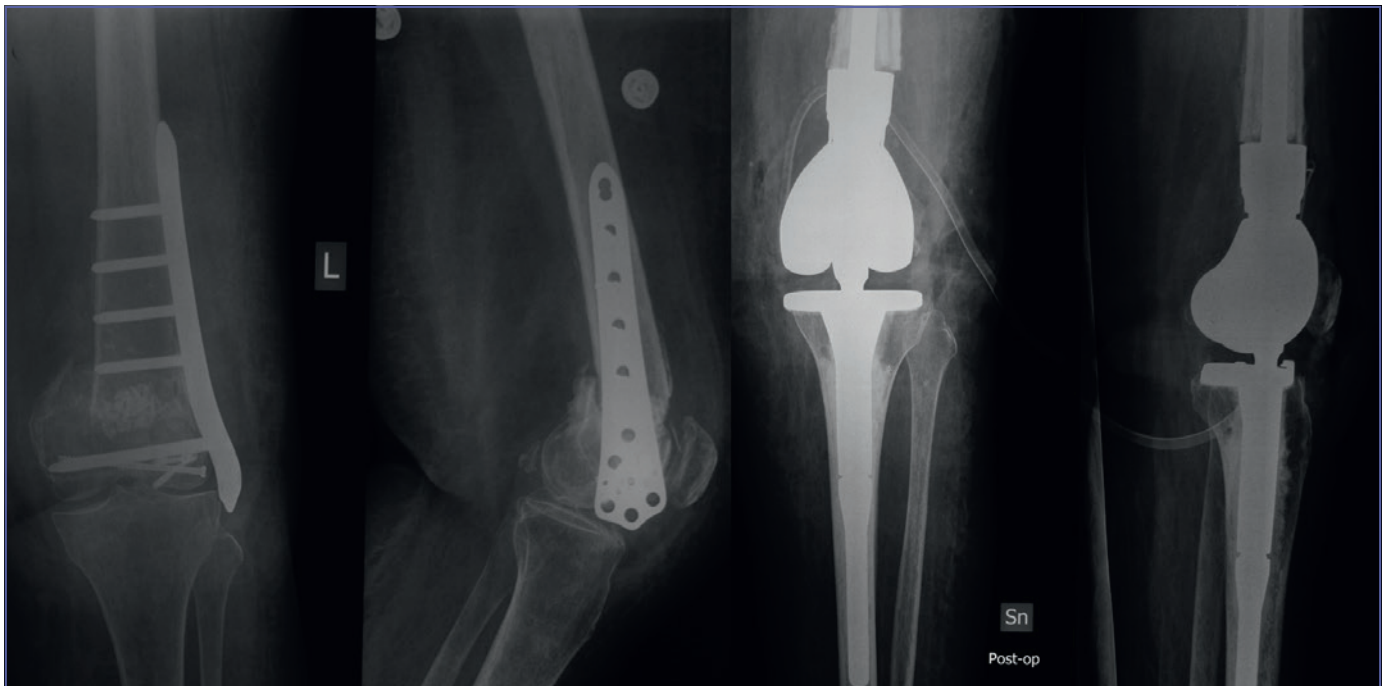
Distal femur nonunion treated with fixed hinge total knee arthroplasty. A) pre-operative x-rays; B) post-operative x-rays.
